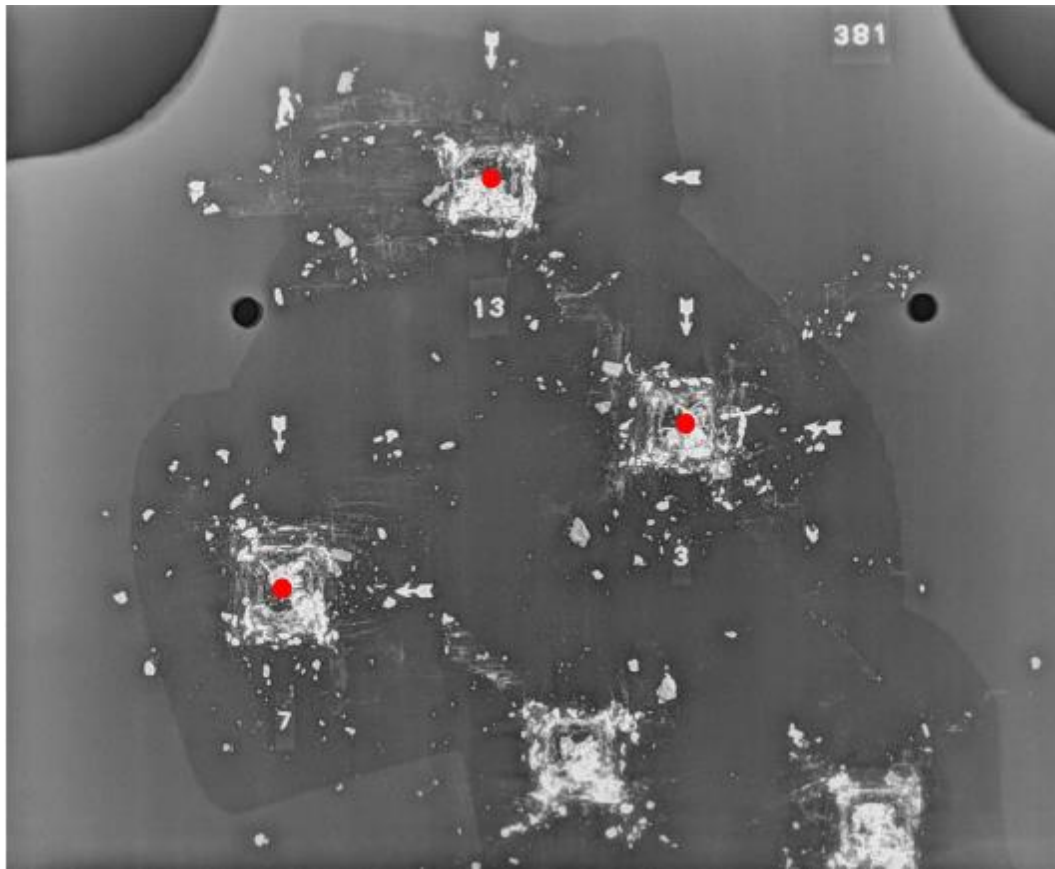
X-ray of one shield tested.
